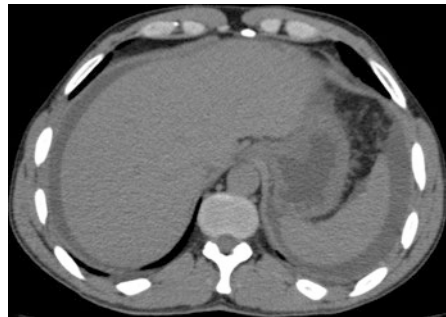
Axial contrast CT image showing pneumoperitoneum
